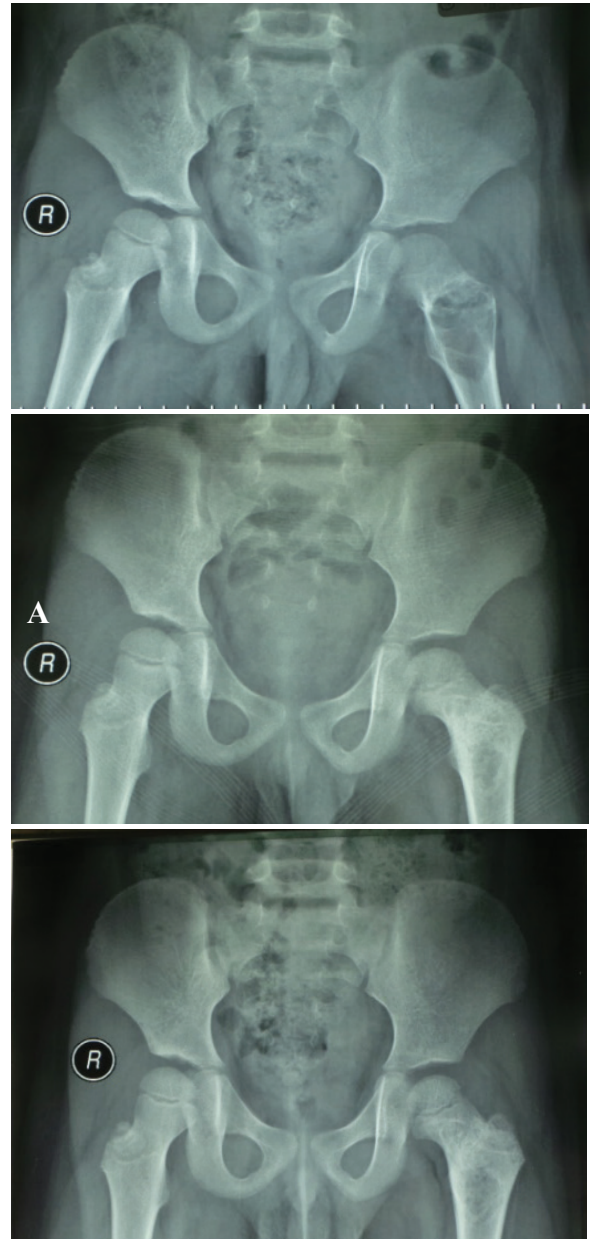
Hip X-Ray of PSI therapy in SBC patient: A. Before surgery, B. Month 6 after surgery, C. Month 12 after surgery.
